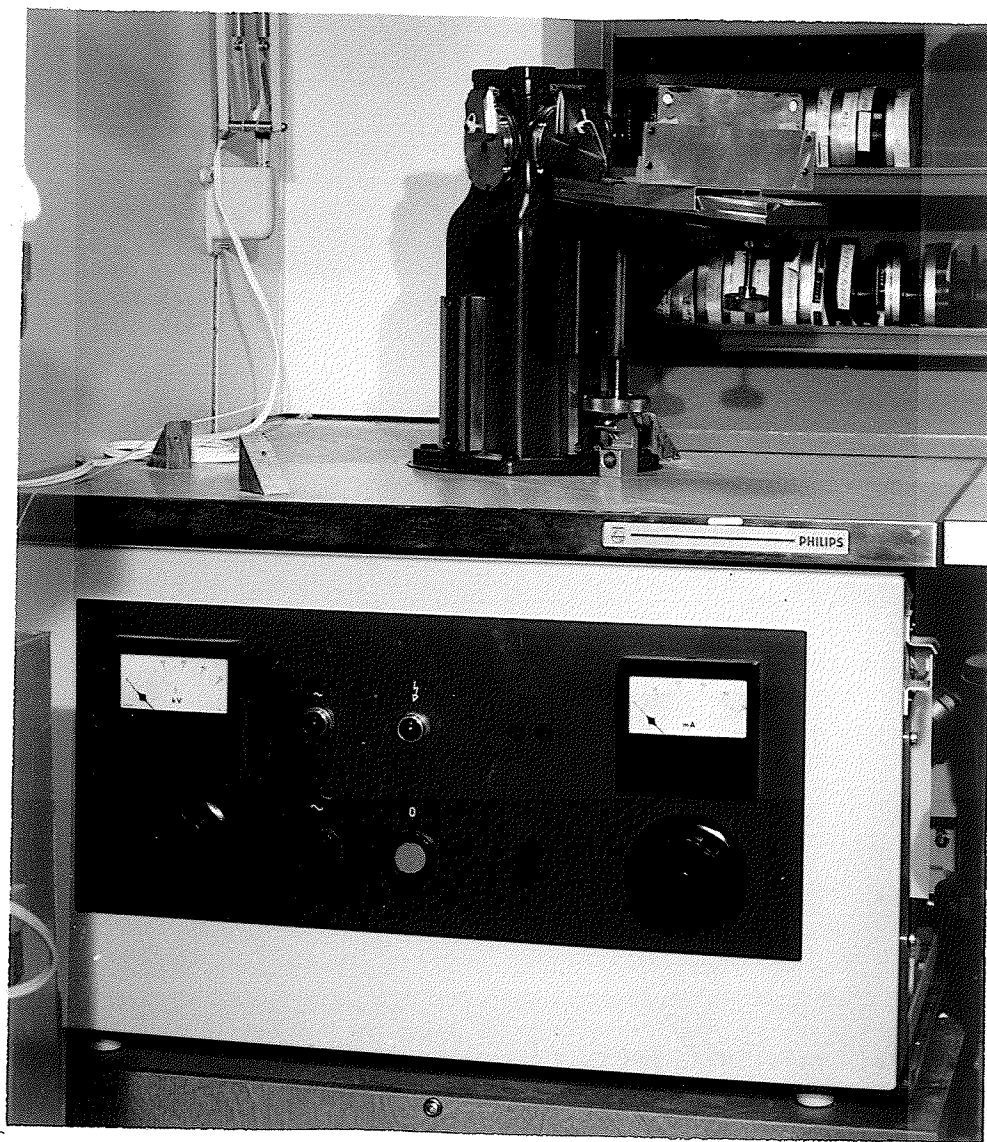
Photograph of the Philips soft x-ray machine used for making the soft x-ray radiographs.
